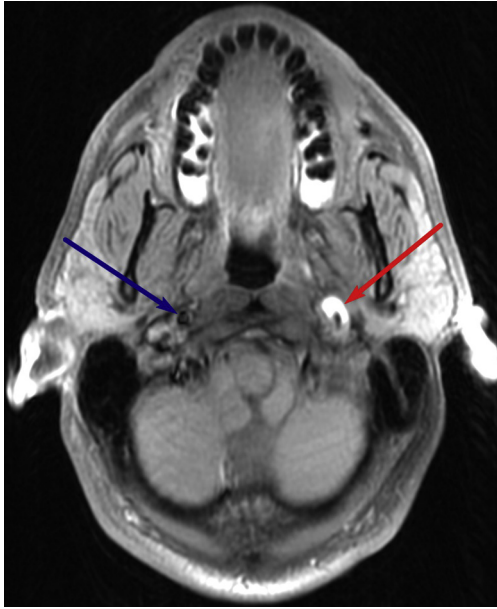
Pseudoaneurysm: Axial T1-weighted fat-saturated image through the upper neck demonstrates dissection of the left internal carotid artery cervical segment with narrowing of the flow-related signal void and a crescentic hyperintense rim (red arrow), compatible with hemorrhage in the subintimal space or false lumen. There is focal dilation at this level, likely representing a thrombosed pseudoaneurysm. The normal right ICA is also visualized (blue arrow). ICA, internal carotid artery.
